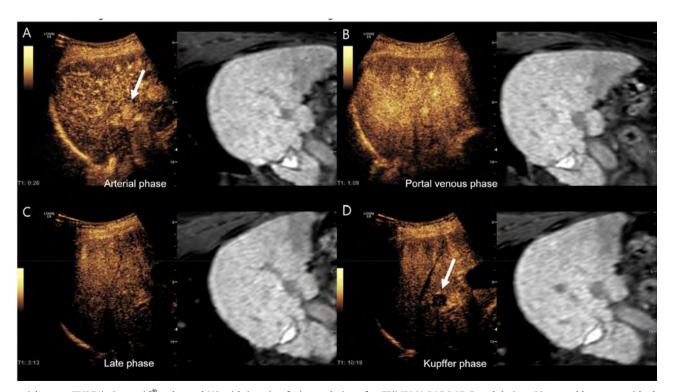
(abstract: FRI274): Sonazoid[®]-enhanced US with imaging fusion technique for CT/MRI LI-RADS LR-5 nodule in a 68-year-old woman with chronic viral hepatitis B. (A) Arterial phase image shows about 1.2 cm hyperenhancing liver nodule (arrow) in hepatic segment VII. (B-C) Portal venous and late phase images show no late and mild washout. (D) There is Kupffer phase defect (arrow). The liver nodule was assigned LR-5 according to modified CEUS, but LR-4 according to CEUS LI-RADS.
